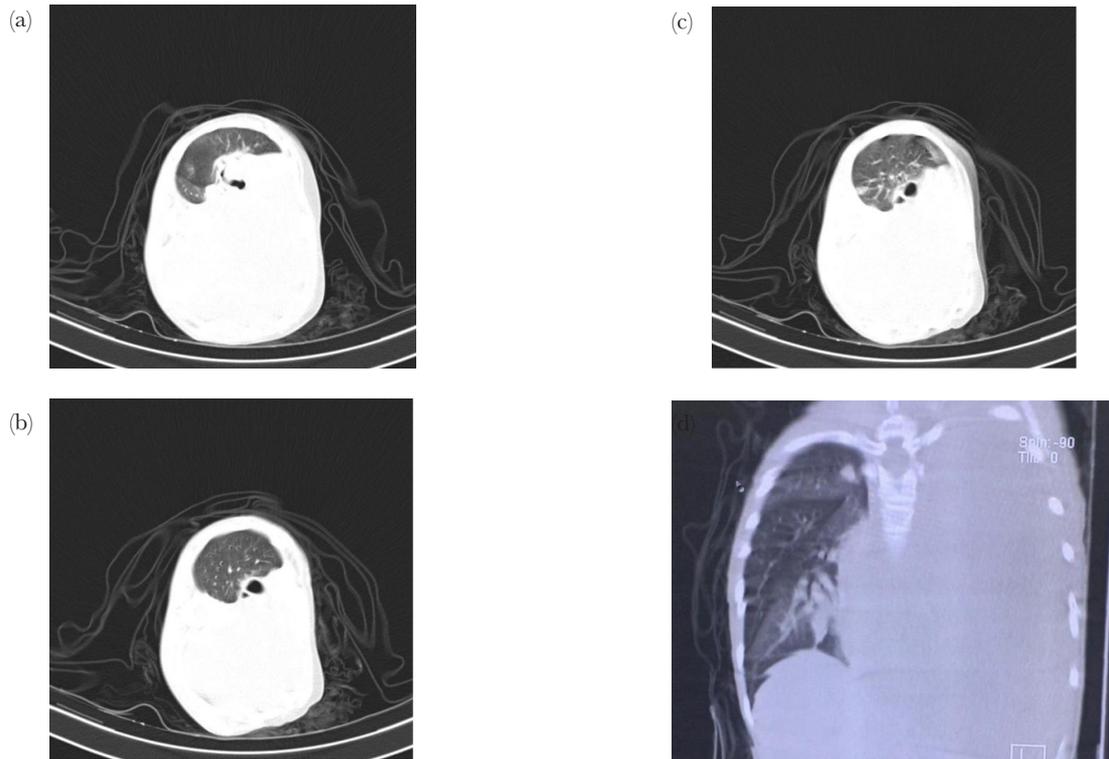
CT-Scan. (a) Taken on the same day as Ro-Thorax. The picture shows, massive opacities in the left lung, subpleural ground-glass opacities in the posterior inferior lobe of the right lung, the right pleura looks normal, the right lung and the heart cannot be assessed. (b) The photo shows, massive opacities in the left lung, rough bronchovascular streak and there is bronchogram in the right lung, the left pleura looks normal, the right lung and the heart cannot be assessed, tracheal distortion to the right. (c) The photo shows, massive opacities in the left lung, rough bronchovascular streak, there is a consolidation of the subpleural area on the posterior and a bronchogram in the right lung, the left pleura appears normal, the right lung and the heart cannot be assessed, tracheal distortion to the right. (d) Massive homogeneous opacities appear from the apex to the basal of the left lung
